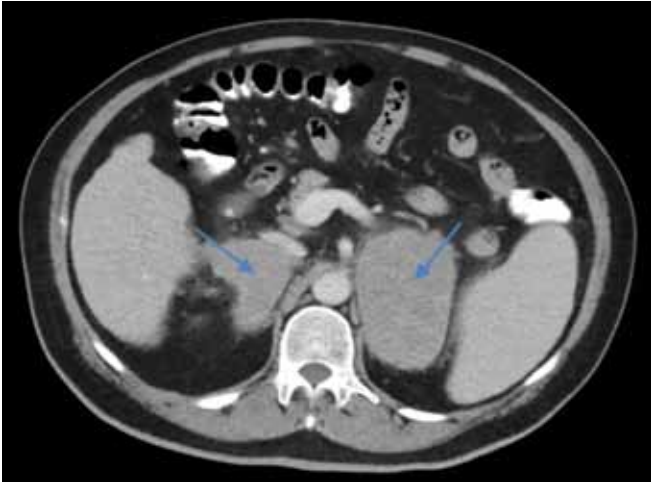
Computed tomography scan showing large bilateral adrenal lesions. The left adrenal measured 8.0 cm, and the right adrenal measured 4.0 cm; axial CT imaging showing bilateral, bulky adrenal masses (arrows point to location of tumors)
